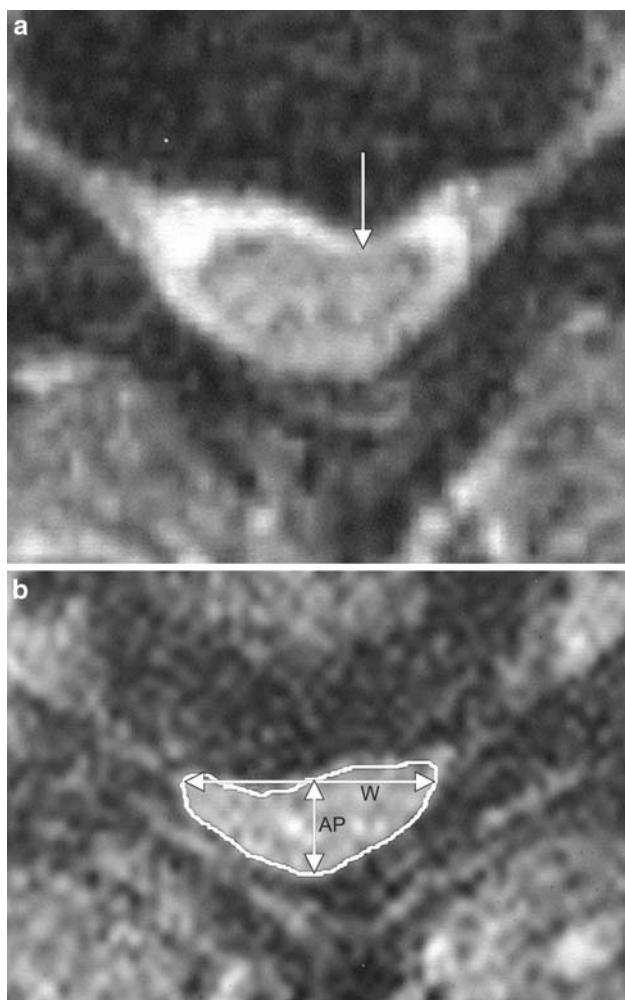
a Axial T2-weighted magnetic resonance image at the C4–C5 level demonstrates ventral impingement (*arrow*) of the spinal cord in the midline as a result of a C4 osteophyte. b Axial T2-weighted magnetic resonance image at the C4–C5 level shows ventral compression of the spinal cord with a *banana-like shape* caused by disc herniation and adjacent osteophytes. The compression ratio was 0.37; the cross-sectional area was 71 mm²
